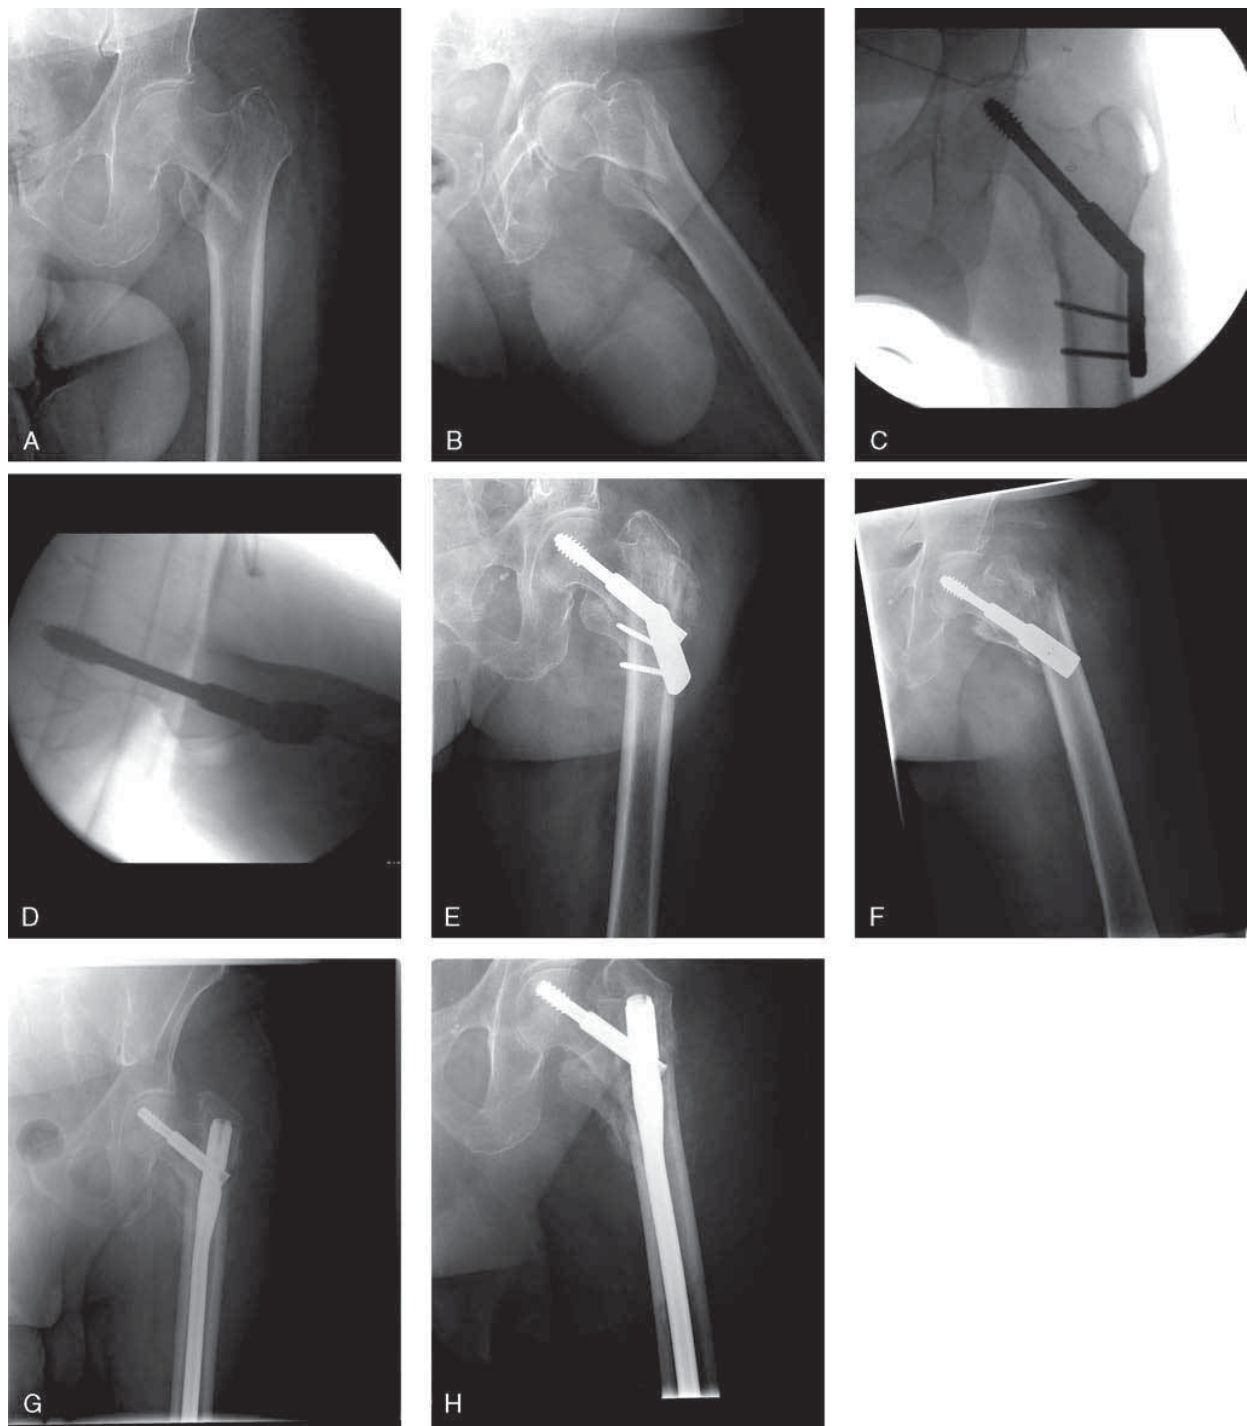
Radiographic views of a pertrochanteric fracture in an 82-year-old man. A and B, Traction AP and frog-leg lateral preoperative views, respectively, are shown. The fracture was believed to be stable, and the patient was treated with a screw and side-plate device; AP and lateral intraoperative views are shown in C and D, respectively. The patient reported increasing pain with ambulation, and at 6 weeks presented with implant failure. E and F, AP and lateral radiographs, respectively, showing implant failure and fracture displacement. The patient had a revision to a long intramedullary implant. G, AP view. H, Frog-leg lateral view.
